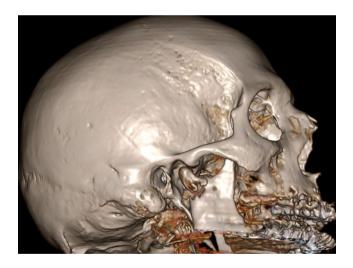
CT scan 3D reconstruction [Colour figure can be viewed at wileyonlinelibrary.com]
